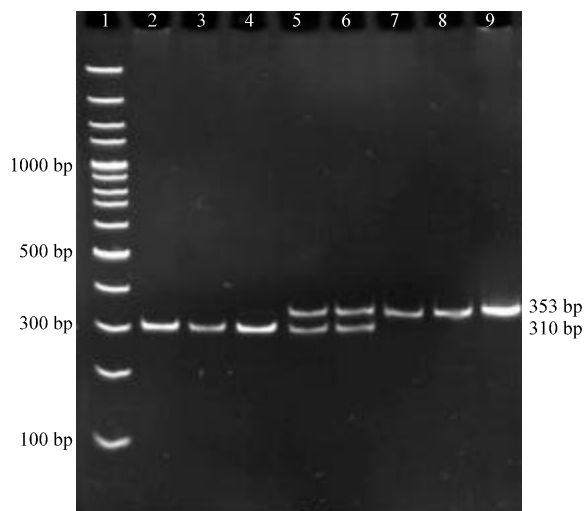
Acryl amide gel electrophoresis of PCR-RFLP in 1173C>T region with restriction enzyme *HinfI*. Lane 1: DNA ladder molecular size marker (100 bp), Lanes 2, 3, 4: 1173 TT, Lanes 5, 6: 1173 CT, Lanes 7, 8, 9: 1173 CC
